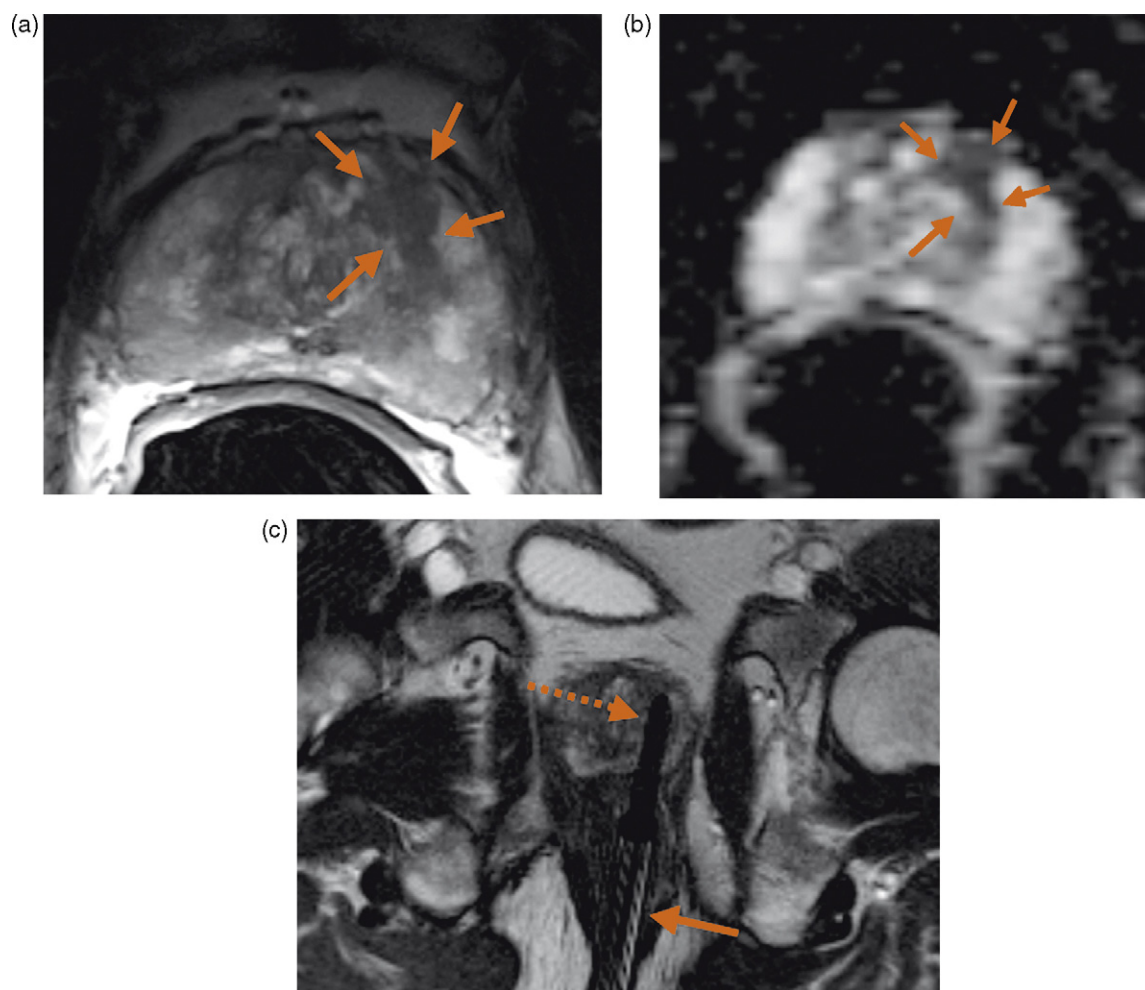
A 64-year-old male with elevated PSA level (14 ng/ml) and two negative TRUSBx sessions underwent MRI of the prostate and subsequent MR-guided biopsy: (a) axial T2-weighted MR image shows the presence of a suspicious area of low signal intensity (arrows) in the left central gland; (b) ADC map at the same level shows a significant reduction in ADC (arrows); (c) coronal T2-weighted MRI related to a biopsy (dotted arrow) of this area that was taken under MR guidance (arrow) and corresponded with prostate cancer (Gleason 4+3). Axial MR images could be obtained to show the needle tip in the area suspected for tumors (see Fig. 2a and b).
